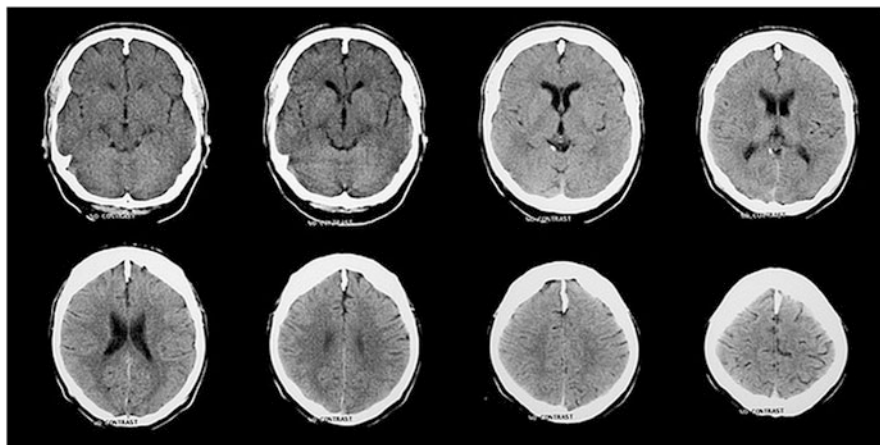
CT showing no alteration in the posterior cranial fossa. Regular and symmetrical fourth ventricle. Normal supratentorial ventricular system. No expansive lesions in supratentorial regions. Normal cortical tropism
